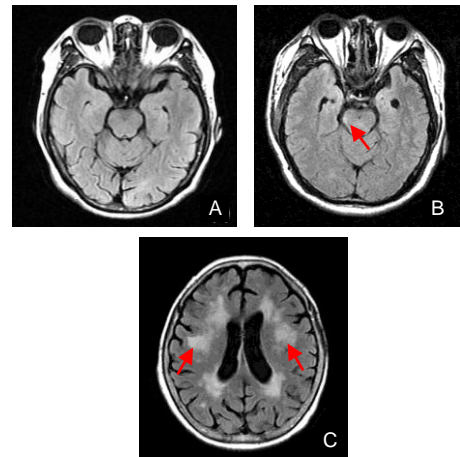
Fluid-attenuated inversion-recovery (FLAIR) images from healthy, axonal injury and demyelinating disease subjects.
